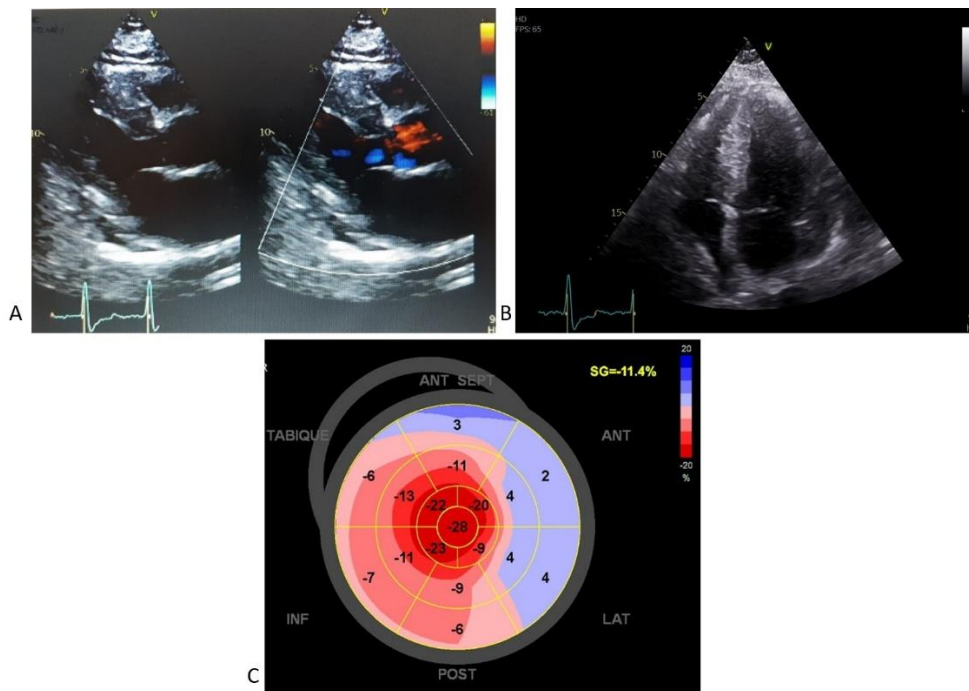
Echocardiogram. A. Parasternal long axis showing severe thickness of interventricular septum and posterior wall. B. Four chamber view showing interventricular septum thickened, biatrial dilation and moderate pericardial effusion. C. Global longitudinal strain -11% with "cherry-on-top" pattern.
